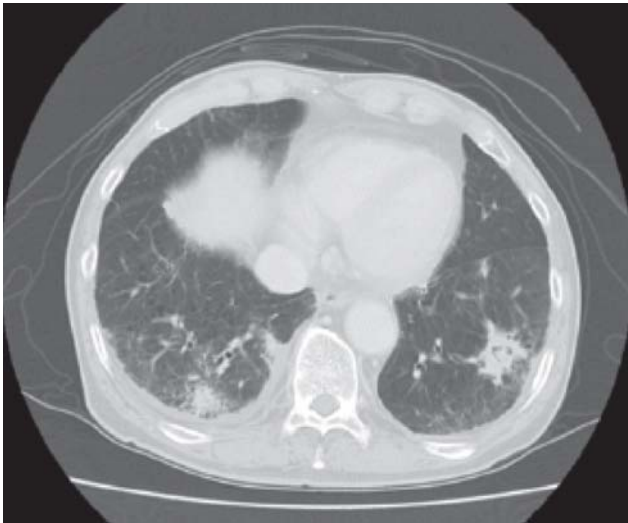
Computed tomography of the chest. Appearance of consolidation at several fields.
